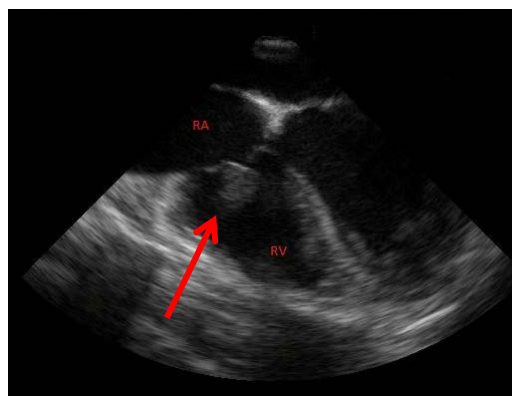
Transesophageal echocardiogram shows the mass. RA: right atrium; RV: right ventricle.
